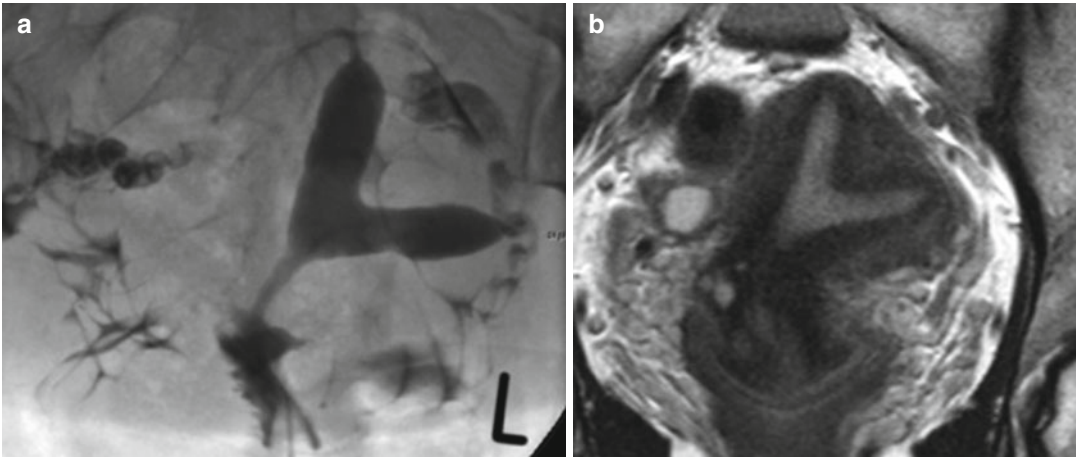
(a, b) HSG and MRI in a woman suffering recurrent miscarriage. The HSG (8a) shows a single cervix and two widely separated uterine cavities The MRI shows that this is a septate cavity.U2a C0 V0
